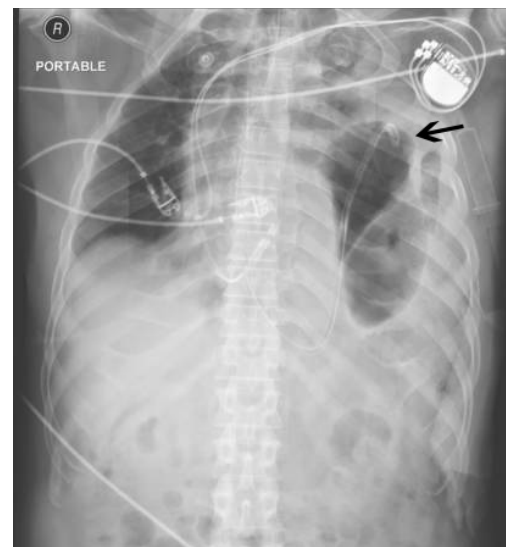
Portable anteroposterior chest x-ray demonstrating successful nasogastric tube insertion with tip extending above ruptured diaphragm into thorax (arrow).
